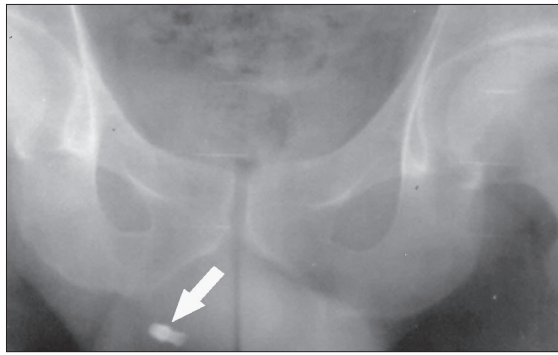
Plain radiography showing visible section of the foreign body.
